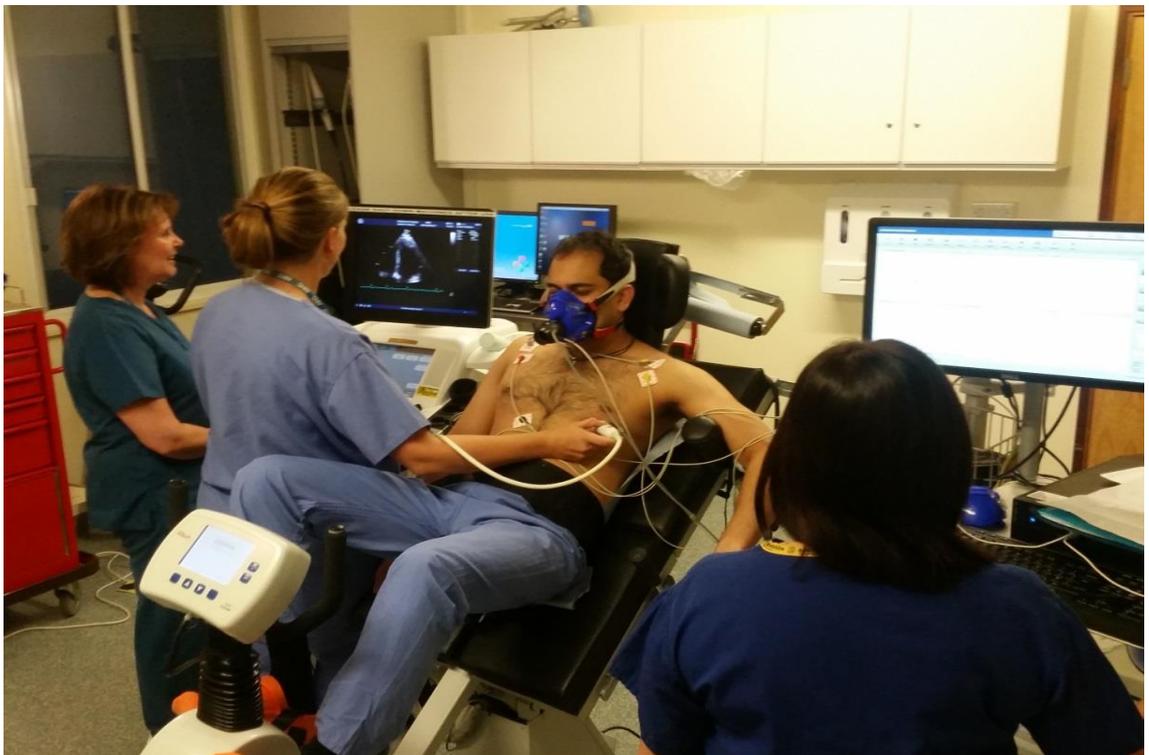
A CPET exercise echocardiogram in action (published with permission from volunteer)
